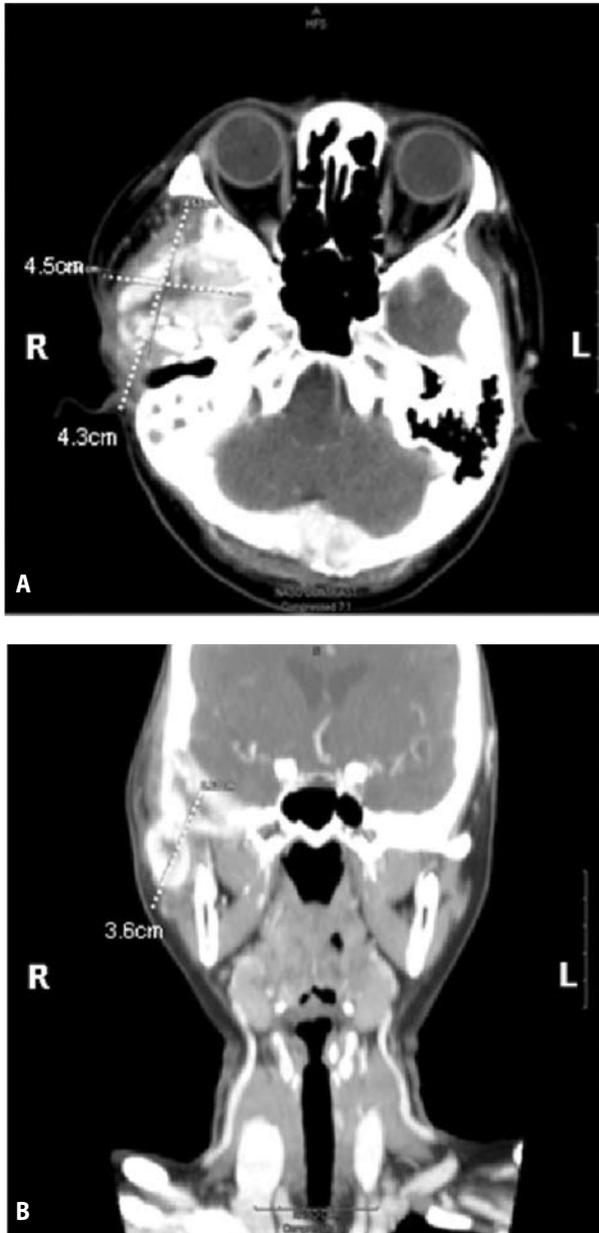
A, B. Post-radiation Contrast CT scan of head, axial and coronal sections showed an interval decrease in size of the previously noted avidly enhancing lobulated soft tissue mass. It now measures 4.5cm x 4.3cm x 3.6cm.
